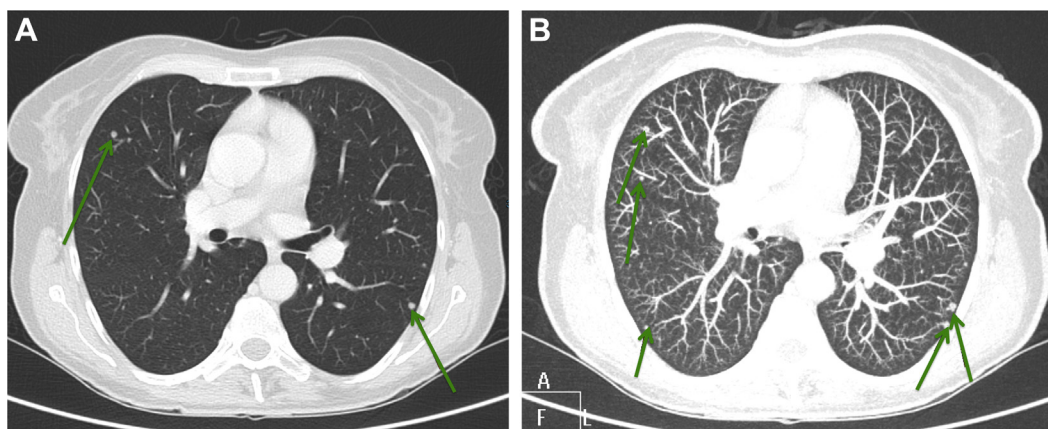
Multiple small pulmonary metastasis (A, green arrows), which are easily distinguished on CT MIP-images (B, green arrows).
